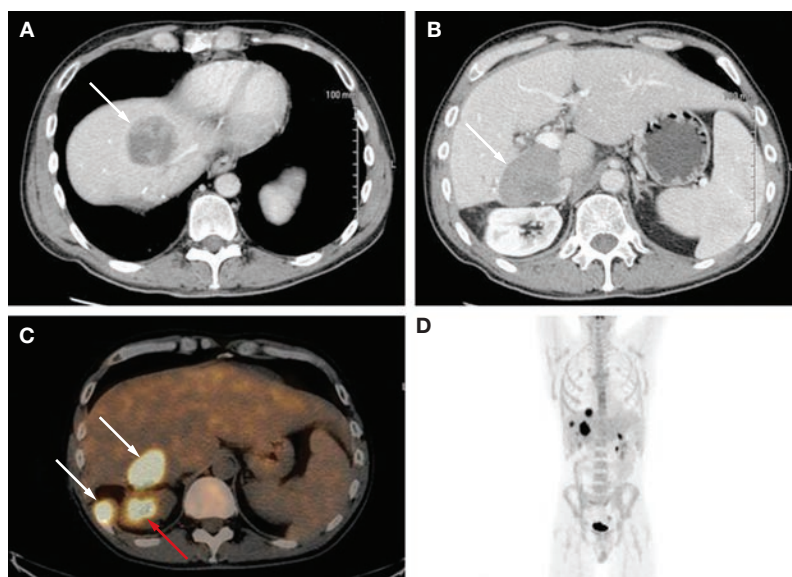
CT, PET-CT and whole-body PET images obtained prior to yttrium-90 microsphere embolization in a patient with diffuse large B-cell lymphoma. (A) CT image showing a prominent hypodense lesion in the dome of the liver (arrow). (B) CT image showing a hypodense lesion in the left lobe of the liver (arrow). (C) PET-CT fusion image showing liver tumors (white arrows) and normal ^{18}F -FDG uptake in the right kidney (red arrow). (D) Whole-body PET image of the patient, showing three FDG-avid liver lesions.
